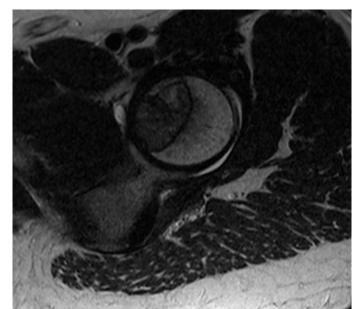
Preoperative axial view MRI showing the lesion in the left femur.
